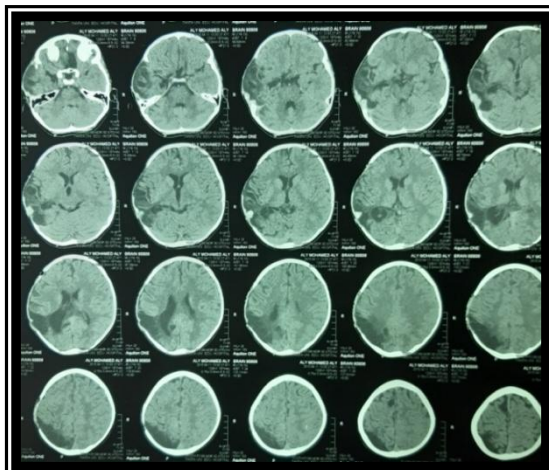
Pre-operative axial CT brain showing bone defect
